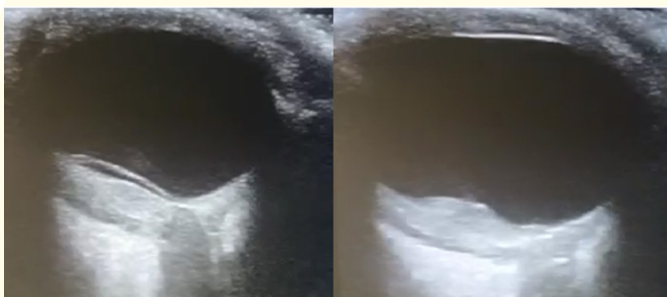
Ocular ultrasound showing a choroidal mass associated with retinal detachment.
